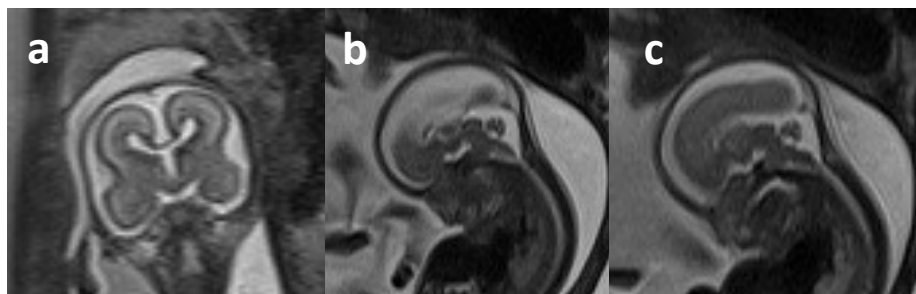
MRI Imaging at 20+4 GW. Agenesis of CSP (a) and cACC (b,c)
